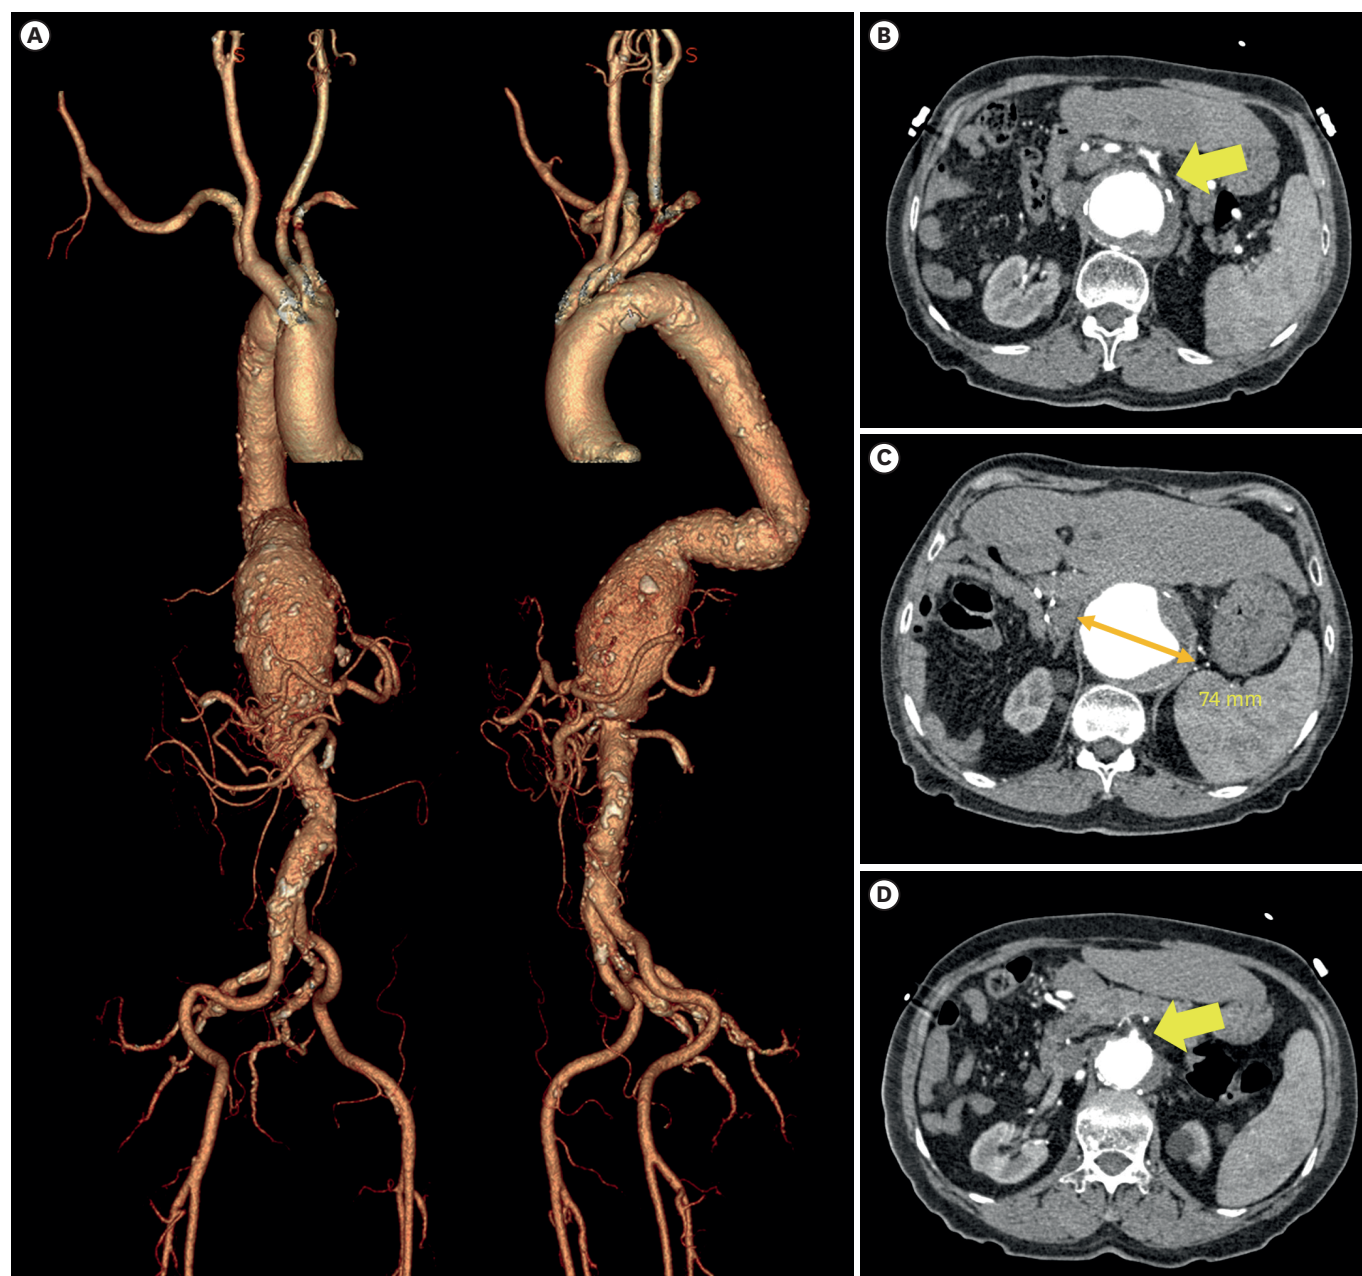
Pre-procedural computed tomography. (A) Volume-rendered 3-dimensional reconstruction image showing a tortuous thoracoabdominal aortic aneurysm with involvement of the visceral arteries. (B) Axial CT image demonstrating occlusion at the ostium of the celiac trunk (arrow). (C) Axial CT image showing the maximum aneurysm diameter of 74 mm. (D) Axial CT image of the distal aneurysmal segment involving the origin of the superior mesenteric artery (arrow). CT = computed tomography.
